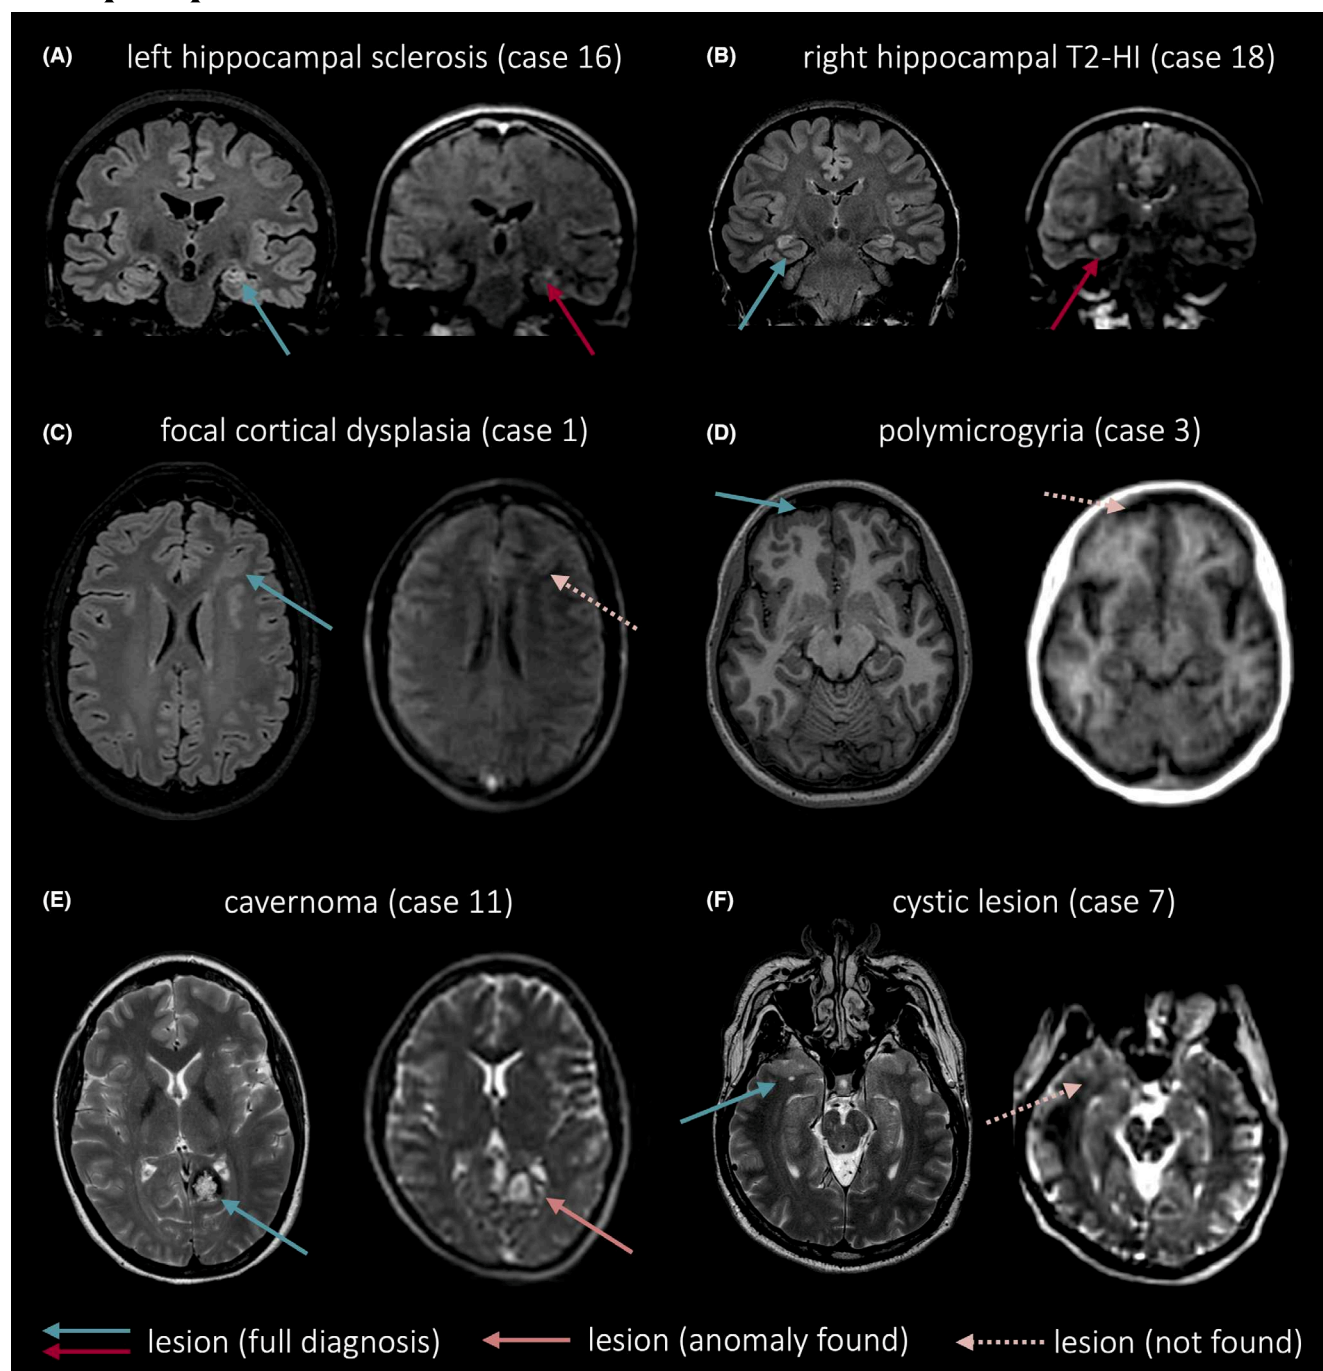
Comparison of clinical high field (HF) magnetic resonance imaging (MRI) and ultra-low-field (ULF) MRI for selected cases with typical epileptogenic lesions. In all panels, clinical HF MRI is shown on the left, and ULF MRI is shown on the right. (A) Coronal fluid-attenuated inversion recovery (FLAIR): left hippocampal sclerosis. (B) Coronal FLAIR: right hippocampal T2 hyperintensity (HI). (C) Axial FLAIR: focal cortical dysplasia. (D) Axial T1-weighted: polymicrogyria. (E) Axial T2-weighted (T2w): cavernoma. (F) Axial T2w: cystic lesion. Arrows mark the relevant lesions; dotted arrows are used when the lesion was not found in neuroradiological readings of ULF MRI.
